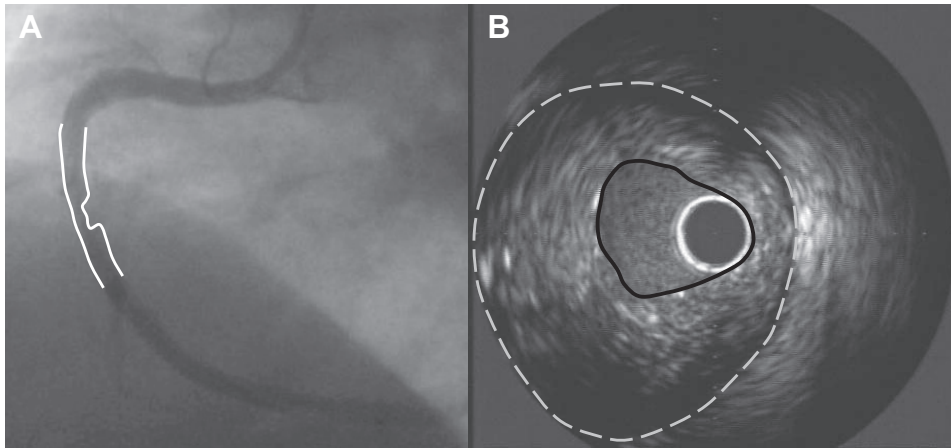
A*: left anterior oblique angiographic view of the right coronary artery demonstrating a moderately significant stenosis in the midsection. The lumen borders in this region are indicated in white. *B*: intravascular ultrasound cross-sectional image demonstrating an eccentric lesion with a minimum lumen area of 3.7 mm<sup>2</sup>. The borders of the lumen (black solid line) and the outer vessel wall (white dotted line) are denoted.
